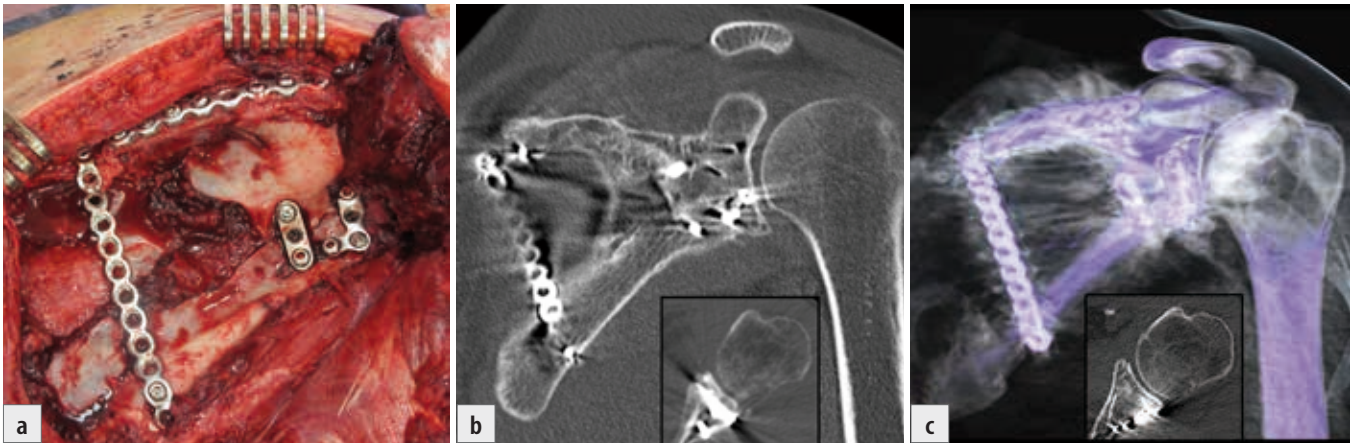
A spanning plate connecting the two pillars in the fracture shown in Fig. 16-4b: a) intraoperative radiograph; b+c) postoperative CT reconstructions.
